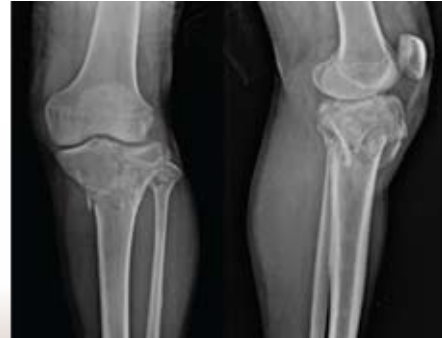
Pre-operative CT – AP and PA projections accurately delineating the fracture pattern
